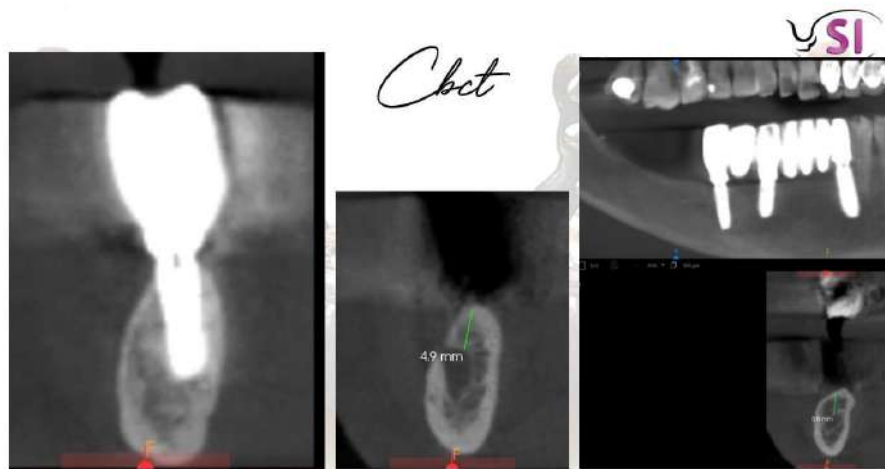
CBCT evaluation.
